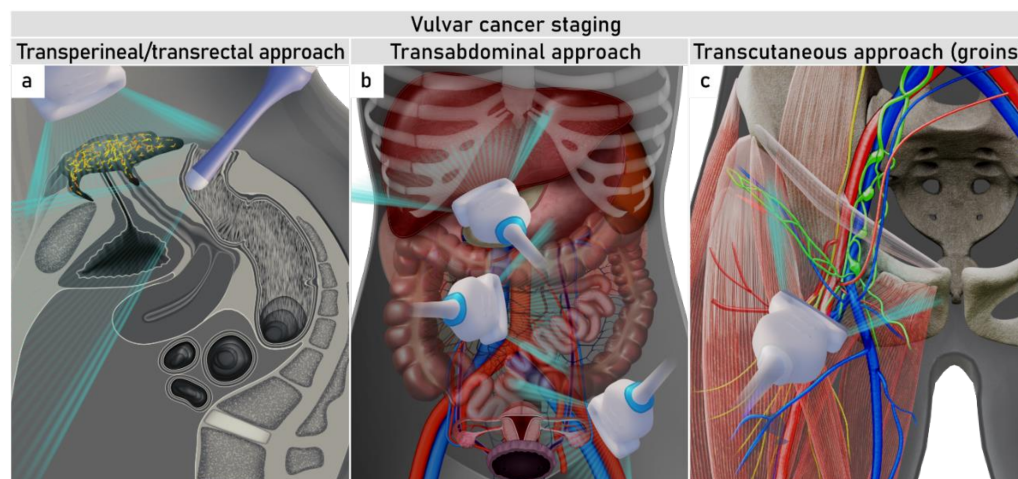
Ultrasound approaches for vulvar cancer staging. Transperineally applied convex or linear array probe for primary tumor assessment in combination with transrectally inserted endoluminal probe to bypass obstruction of the vaginal introitus by a large vulvar cancer (a). Transabdominal approach using a convex array probe for evaluation of distant metastases (b). Transcutaneous approach with linear array probe for inguinofemoral lymph nodes evaluation (c).
